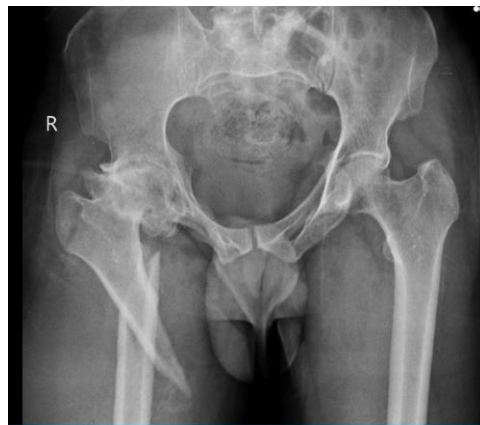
Pre-operative X-ray of both right leg showing sub-trochanteric fracture with osteoarthritis of right hip.
